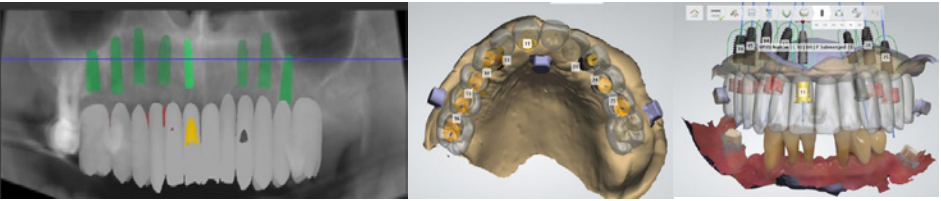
Data (CT Data & Intraoral Scan Data) and mock surgery through digital imaging devices
